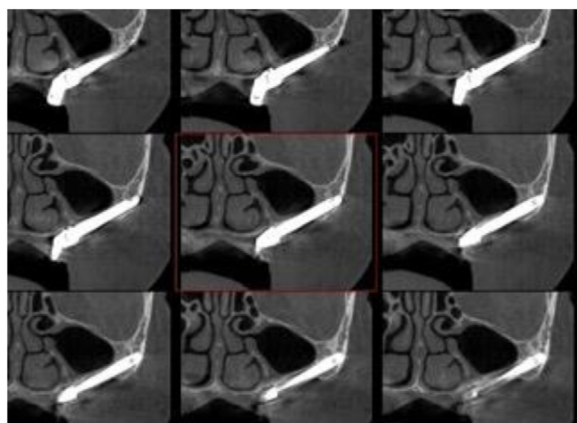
Final computed tomography where the prototype passive fit to the remaining zygomatic implant may be verified.
